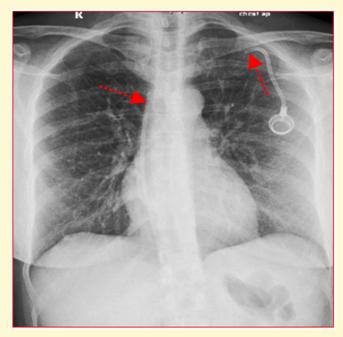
Frontal Chest Radiograph showing Broken Chemoport
